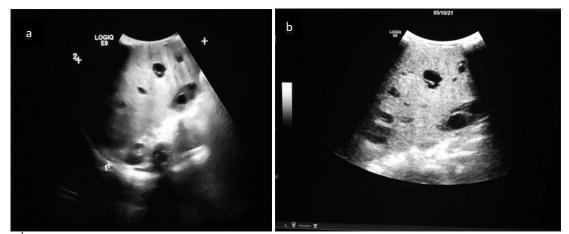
(a and b): Abdominal ultrasound shows a mass at the expense of the multi-cystic heterogeneous left liver
